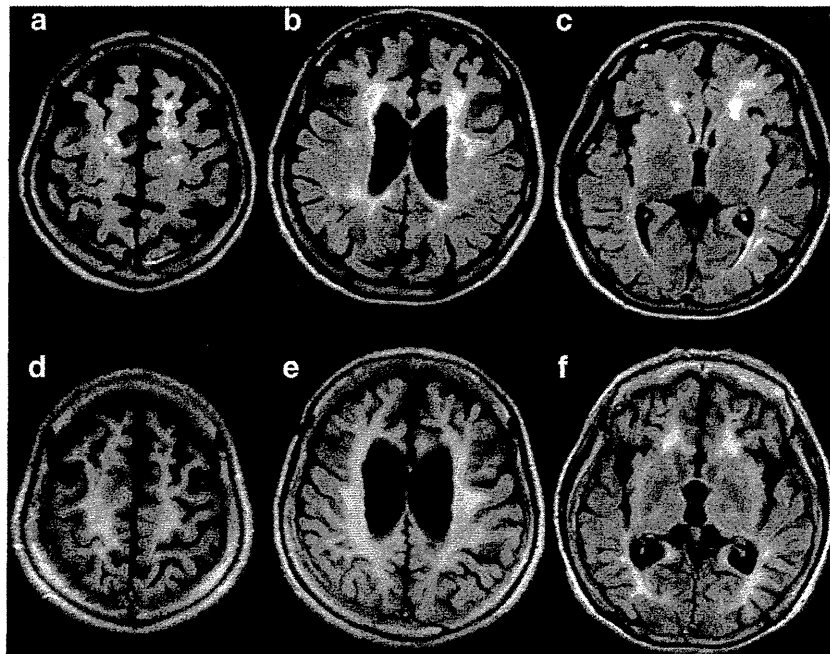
Serial MRI flair images. The first examination showed multiple small lacuna-like lesions in deep white matter (a, b and c), but in the second examination (d, e and f) these small lesions had become confluent, revealing extensive high signal intensity areas in cerebral white matter.
